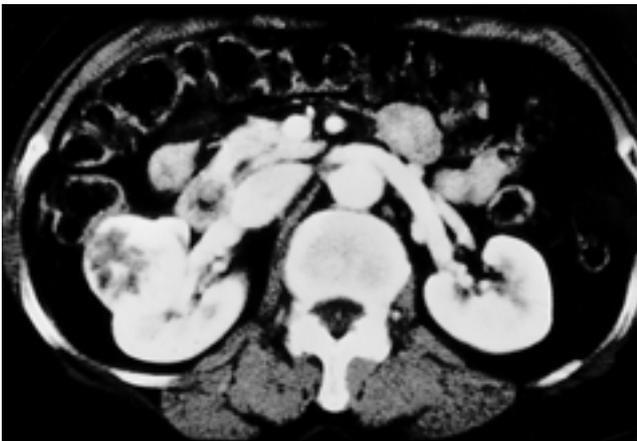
CT shows 3 cm sized, heterogeneously well-enhancing mass in right kidney. CT stage was T2 by old classification but now T1 by new TNM classification.
